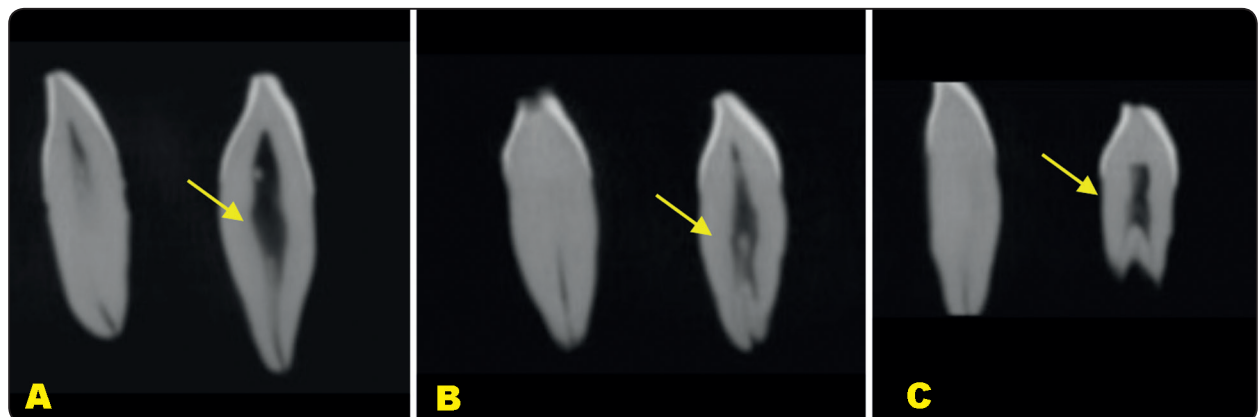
(A) Cone beam computed tomography (CBCT) showing C with type I (yellow arrow) root canal configuration, (B) CBCT showing C with type IV (yellow arrow) root canal configuration, (C) CBCT showing C with type V (yellow arrow) root canal configuration.
